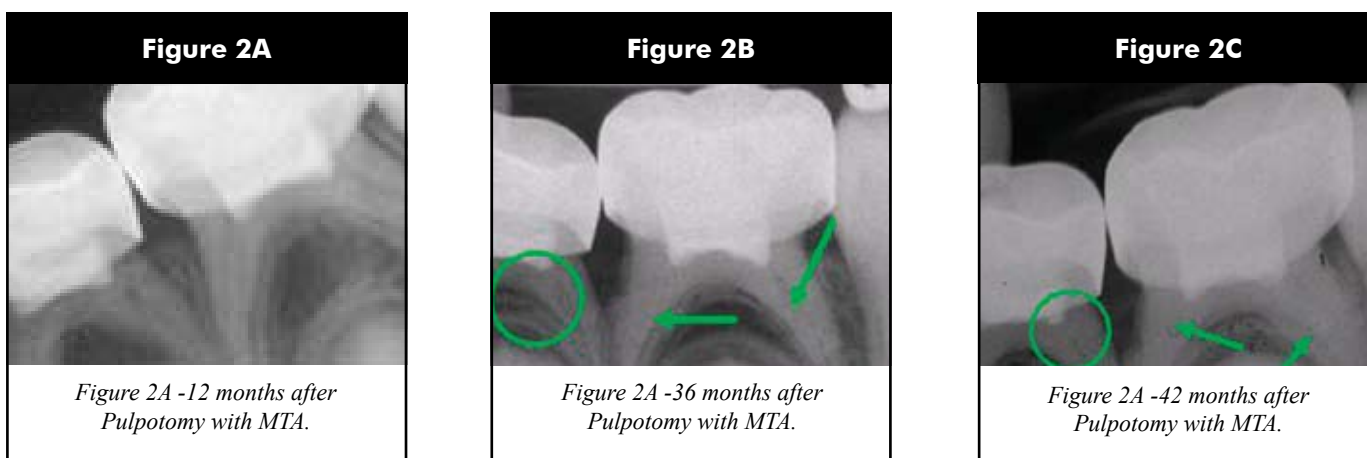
Radiograph of first and second lower left primary molar.
